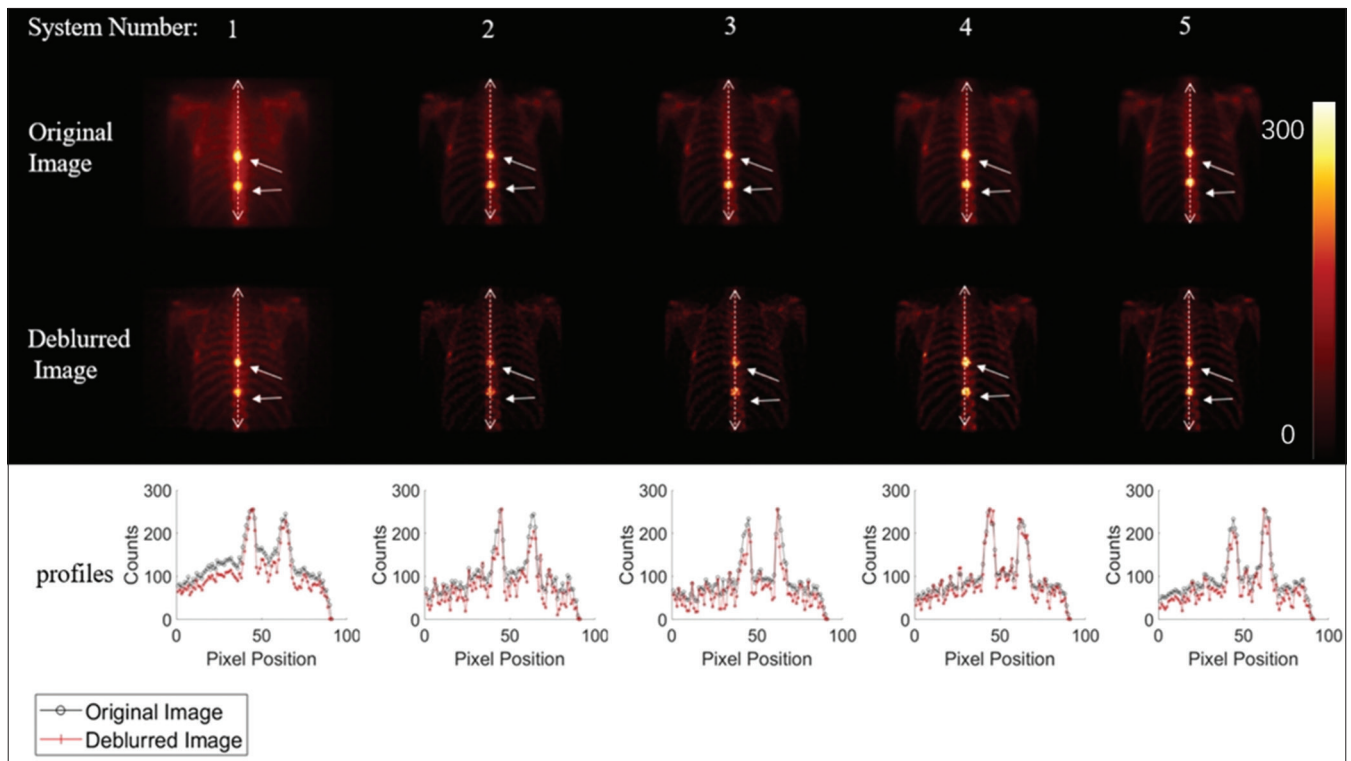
Comparison before and after blind deconvolution for different single-photon emission computed tomography collimators. The unit of color bar is counts, presenting the number of events detected. The five columns share the same color bar. In the upper part of the image, the bidirectional arrow represents the section line, while the unidirectional arrow points to the location of the tumor. The lower part of the image shows the counts corresponding to the position of the section line
